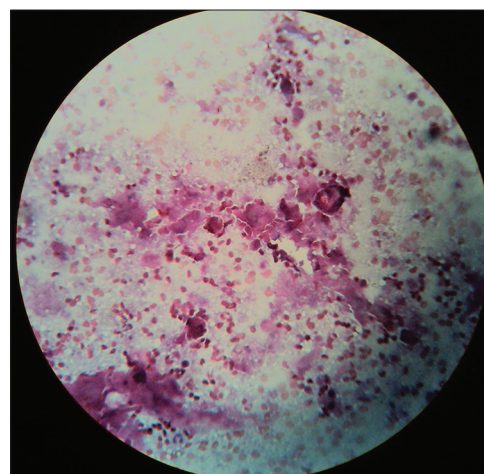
Computed tomography fine needle aspiration cytology showing keratin pearl with malignant cell suggestive of a squamous cell carcinoma
